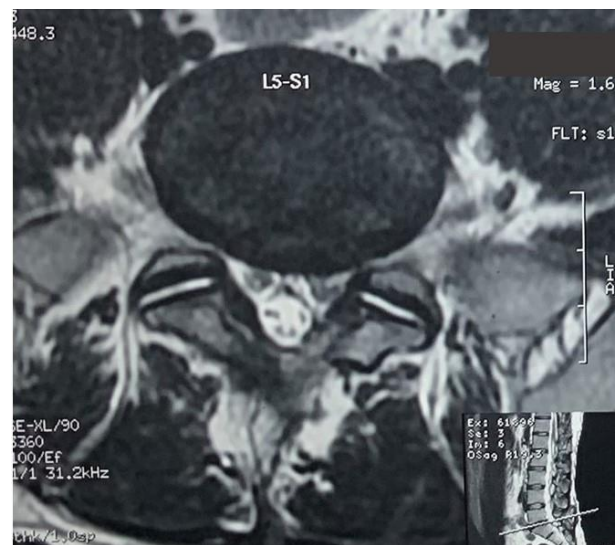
Post-operative axial MRI image of same patient as in Figure-4.
